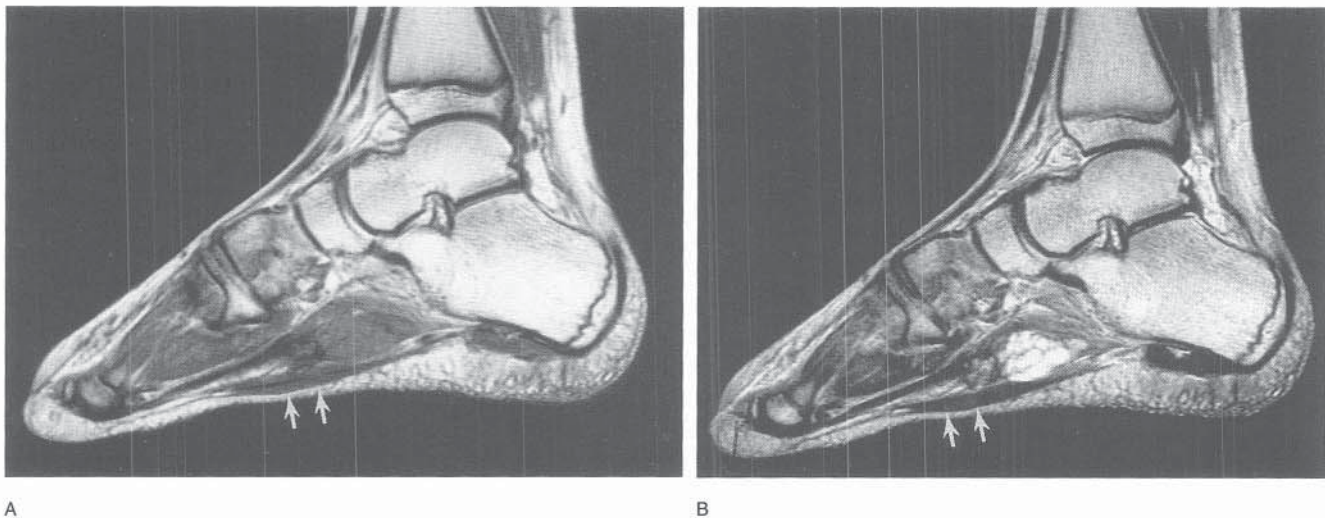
A 13-year-old boy presented with a 3-month history of plantar left foot pain that was worsened by activity and improved with rest. A, A sagittal T1-weighted image revealed an ovoid, intermediate-signal-intensity mass deep to the flexor digitorum brevis muscle (arrows). The differential diagnosis would include a vascular lesion, a tumor associated with a tendon, an inflammatory process secondary to a foreign body, and a synovial sarcoma. B, A sagittal T2-weighted image showed abnormal cystlike regions of increased signal intensity, suggesting a venous malformation. Because the patient had persistent pain, a biopsy was performed and revealed a venous malformation.
